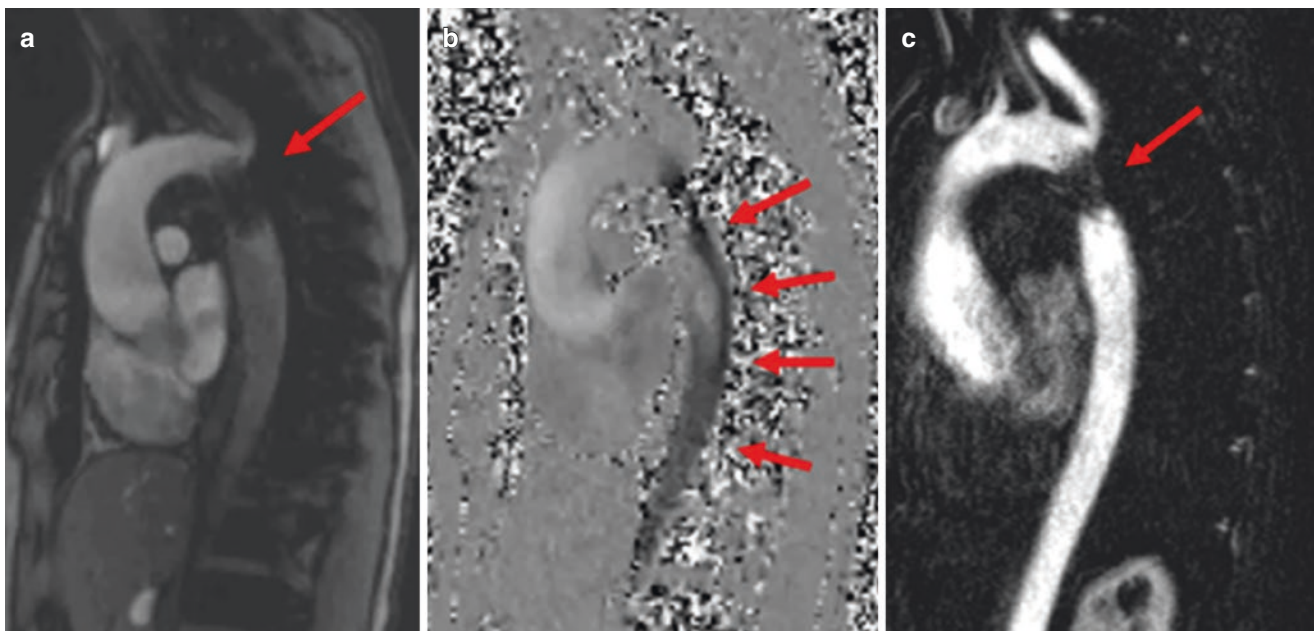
Patient with repaired aortic coarctation. (a) 2D SSFP oblique sagittal view showing the stent at the aortic isthmus (arrow). (b) Phase contrast MRI shows flow through the stent (black signal—arrow). (c) Maximum-intensity projection image from the contrast-enhanced MR angiography showing the adequate position of the stent in the aortic isthmus
